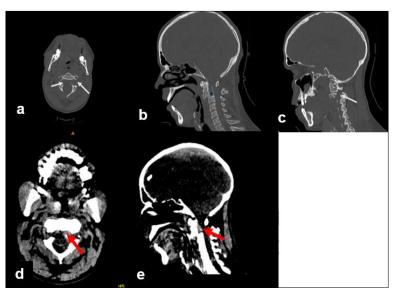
CT scan, bone window on axial (a), sagittal (b and c) planes; parenchymal window on axial (d), sagittal (e) planes
